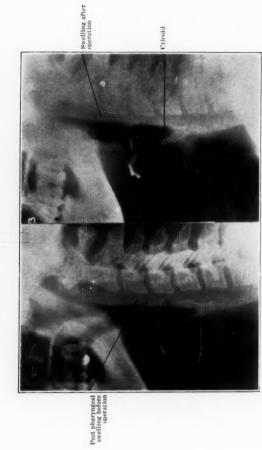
Mulvey. X-ray before and after operation to show the postpharyngeal swelling. This rapidly decreased after exploration of the base of the skull by the pharyngomaxillary route.
